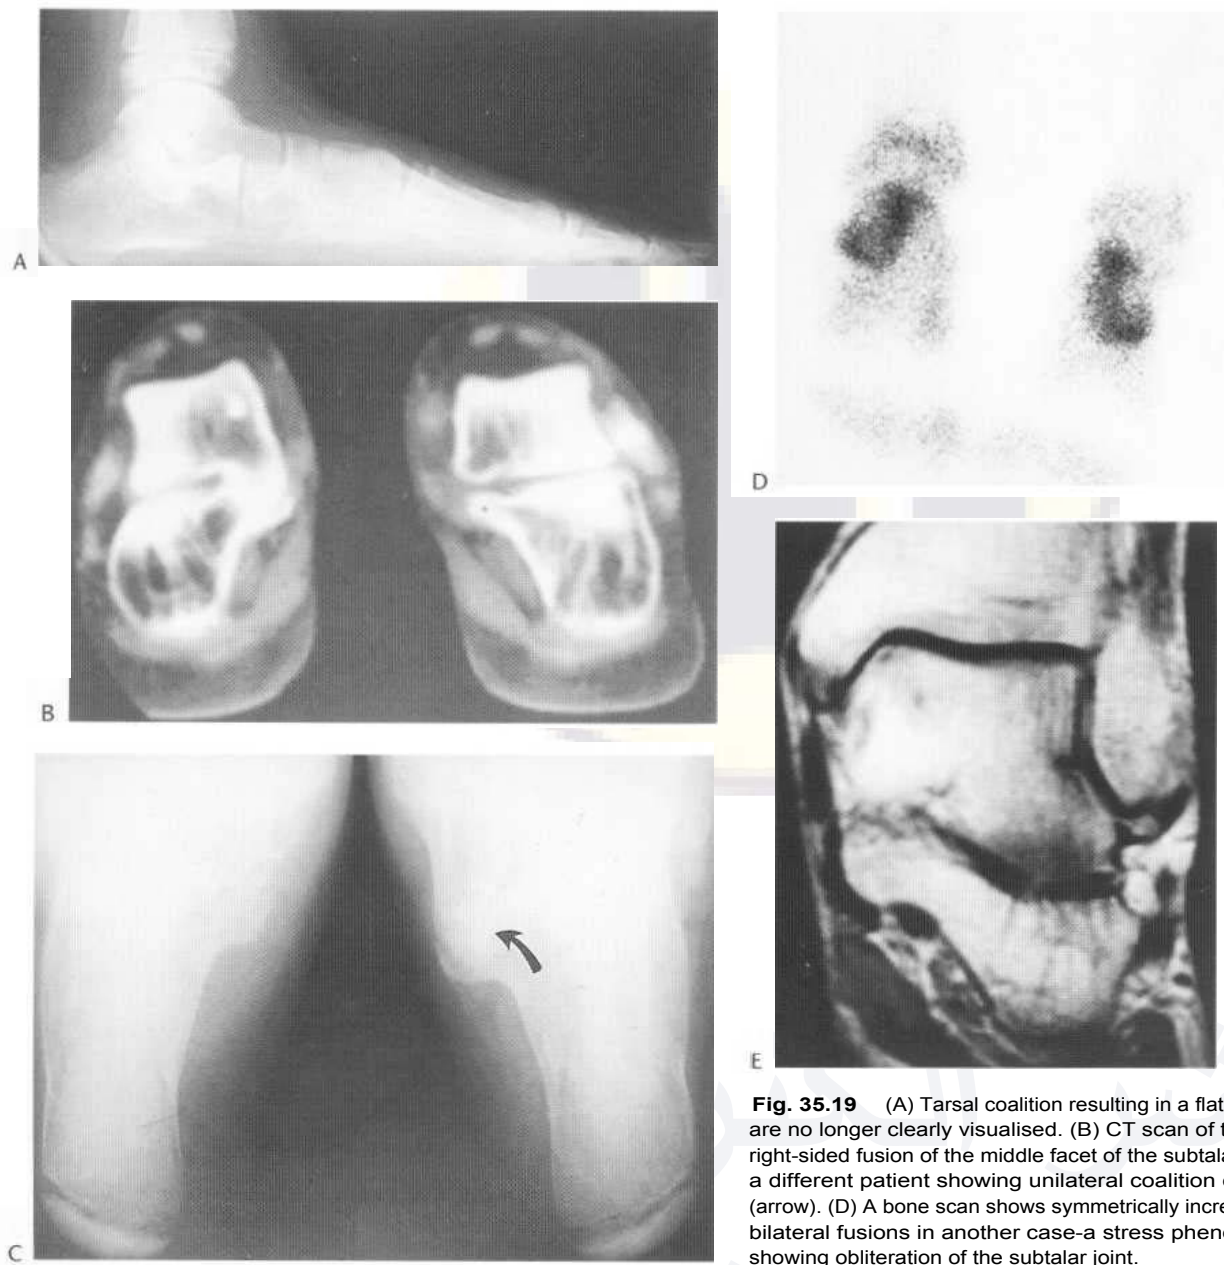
(A) Tarsal coalition resulting in a flat foot. The subtalar joints are no longer clearly visualised. (B) CT scan of tarsal coalition showing right-sided fusion of the middle facet of the subtalar joint. (C) Axial view in a different patient showing unilateral coalition of the left middle facet (arrow). (D) A bone scan shows symmetrically increased uptake away from bilateral fusions in another case—a stress phenomenon. (E) MR scan showing obliteration of the subtalar joint.
